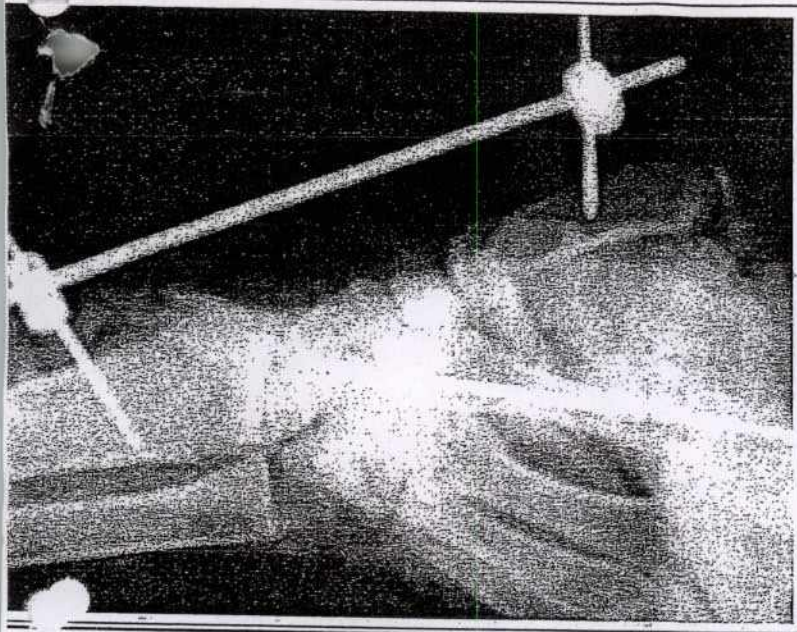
Post-operative X-ray stabilised by ligamentotaxis.
